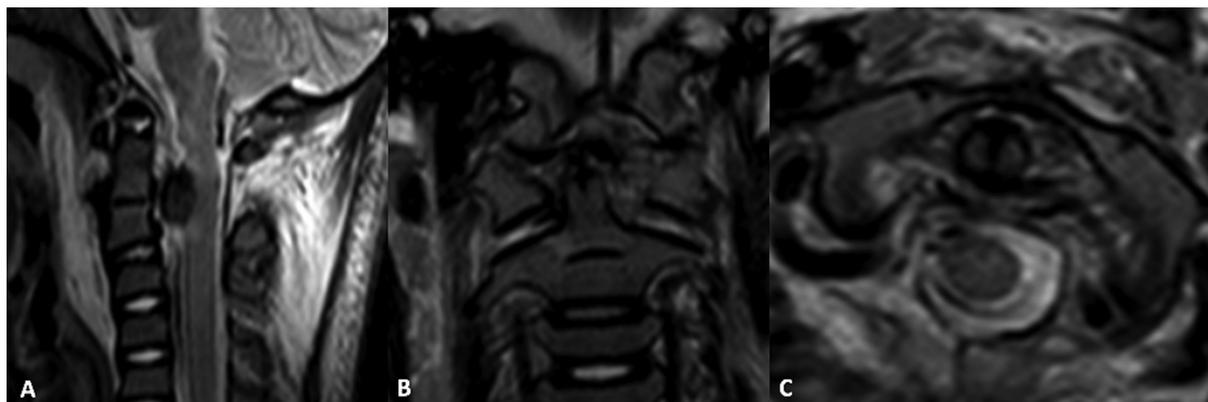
Cervical magnetic resonance imaging (MRI). (A) Evident hypointense collection on anterior spine canal, causing spinal cord edema, compatible with subacute hemorrhage. There is diffuse hyperintensity on nuchal ligaments. (B) On coronal plane, a left-right asymmetry and also a left alar hyperintensity are evident. (C) The transverse ligament was preserved as on method.
